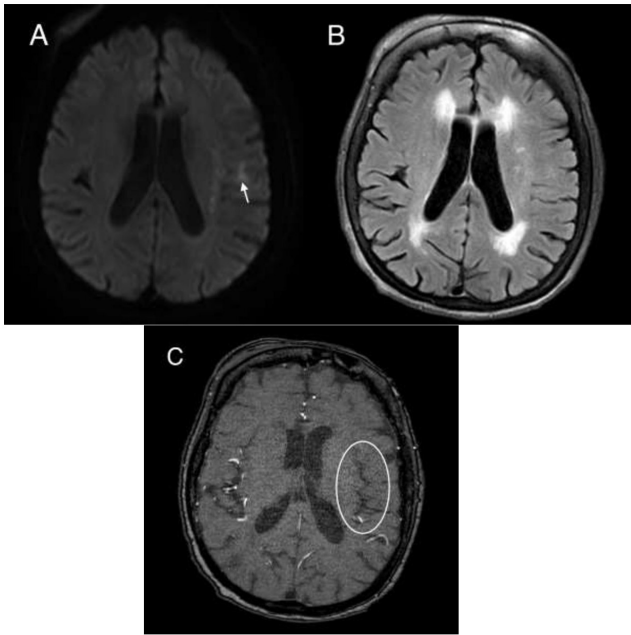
A – Axial DWI image (b=1000) shows a left parietal region acute infarct (white arrow). B – The corresponding axial FLAIR image shows no increased signal at the same region (FLAIR-negative). C – Absence of signal within the vessels at the left M2 region (white circle) compared to the contralateral side, secondary to occlusion.
